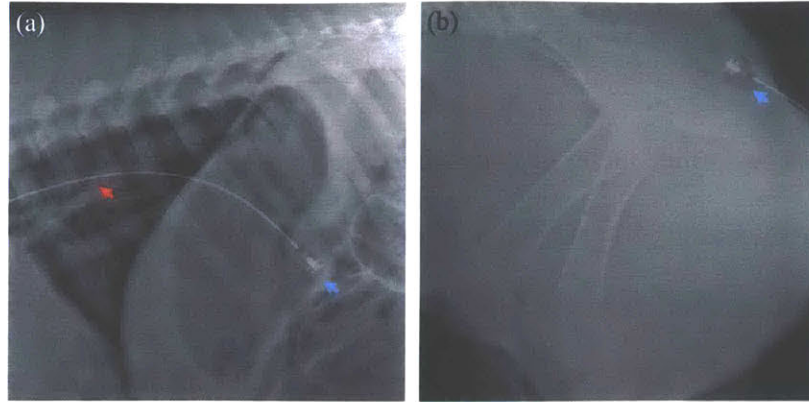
Representative X-rays showing the position of the capsule in the (a) stomach and (b) anal canal. The tether (red arrow) and capsule (blue) are indicated.
